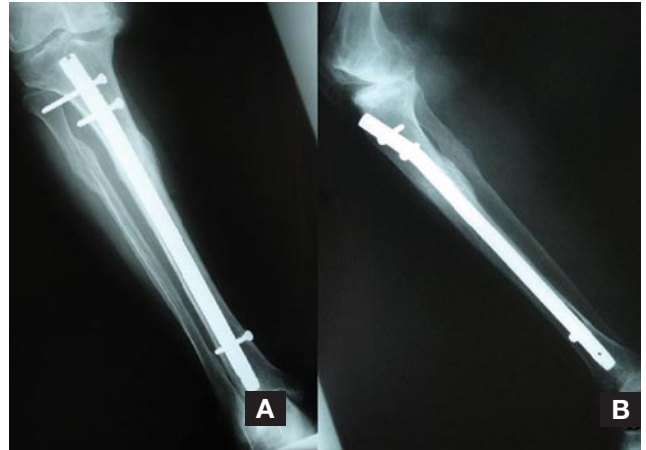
Case 2—postoperative anteroposterior (A) and lateral (B) radiographs.
